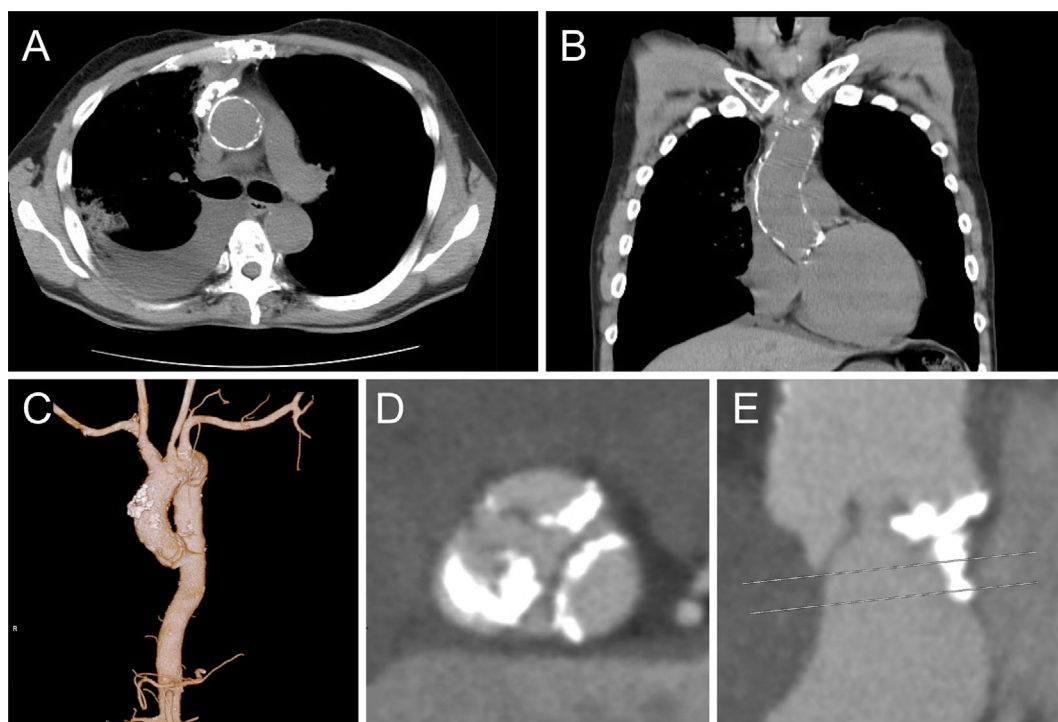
Chest CT [mediastinal window, axial view (A), coronal view (B)] showing porcelain aorta and hostile thorax caused by radiation therapy. (C) 3D image of the aorta showing heavy calcification in the ascending aorta. (D) Short-axis view of the aortic valve. All three cusps are severely calcified, especially in the non-coronary cusp. (E) A self-expandable valve is suitable for the icicle calcification in the left ventricular outflow tract. Residual aortic regurgitation is also attributable to the calcification.
